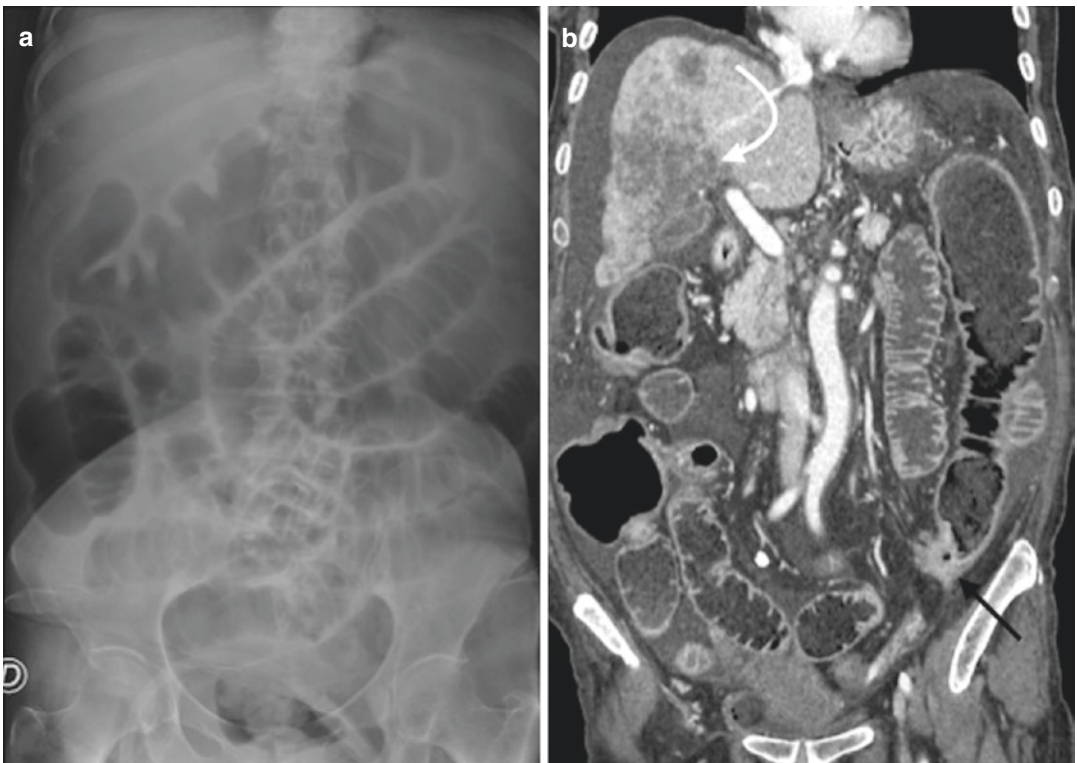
Abdominal radiograph in AP projection (a) and CT in coronal view (b) of an 86-year-old male with intestinal obstruction. Note the small and large bowel overdistension due to mechanical ileus. CT (b) clarifies the etiology of obstruction due to colon cancer obstructing the lumen (b, straight arrow). Liver metastases are also present (b, curved arrow)
